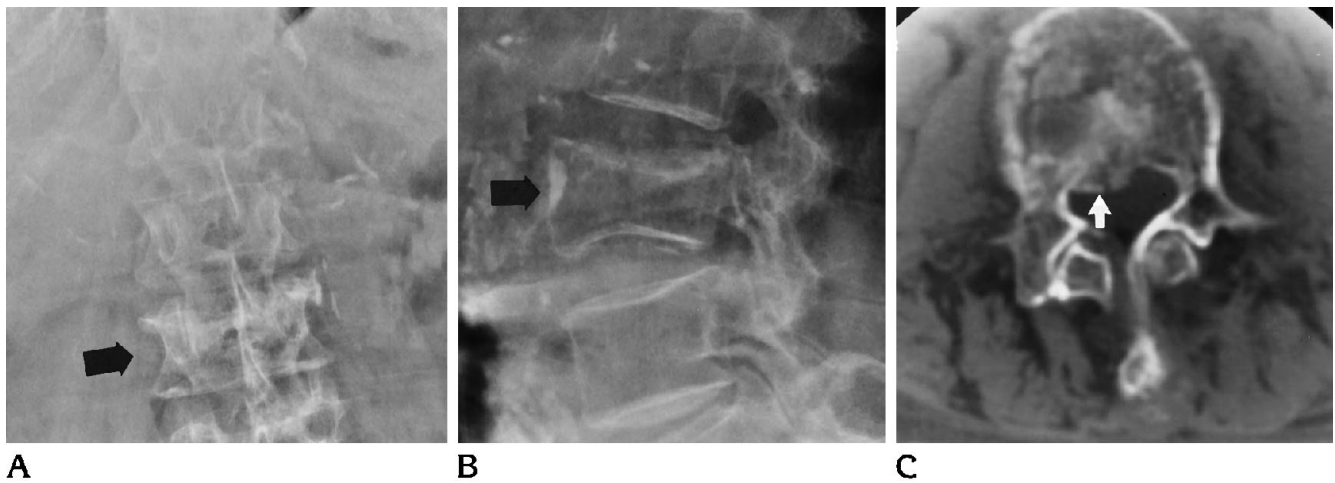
A* and *B*, Plain films (anteroposterior and lateral) do not reveal any evidence of instability of this L-3 fracture (*black arrows*). There is just less than 50% compression of the vertebral body. This case was called stable by three of six plain-film readers. *C*, CT scan of L-3 reveals a burst-type fracture with 25% to 50% compromise of the spinal canal (*white arrow*).
